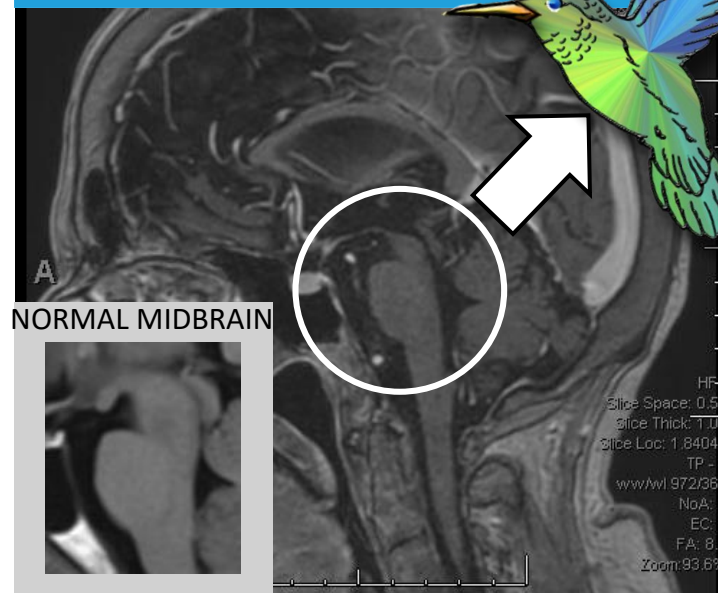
MRI positive for "hummingbird's sign" related to midbrain atrophy
